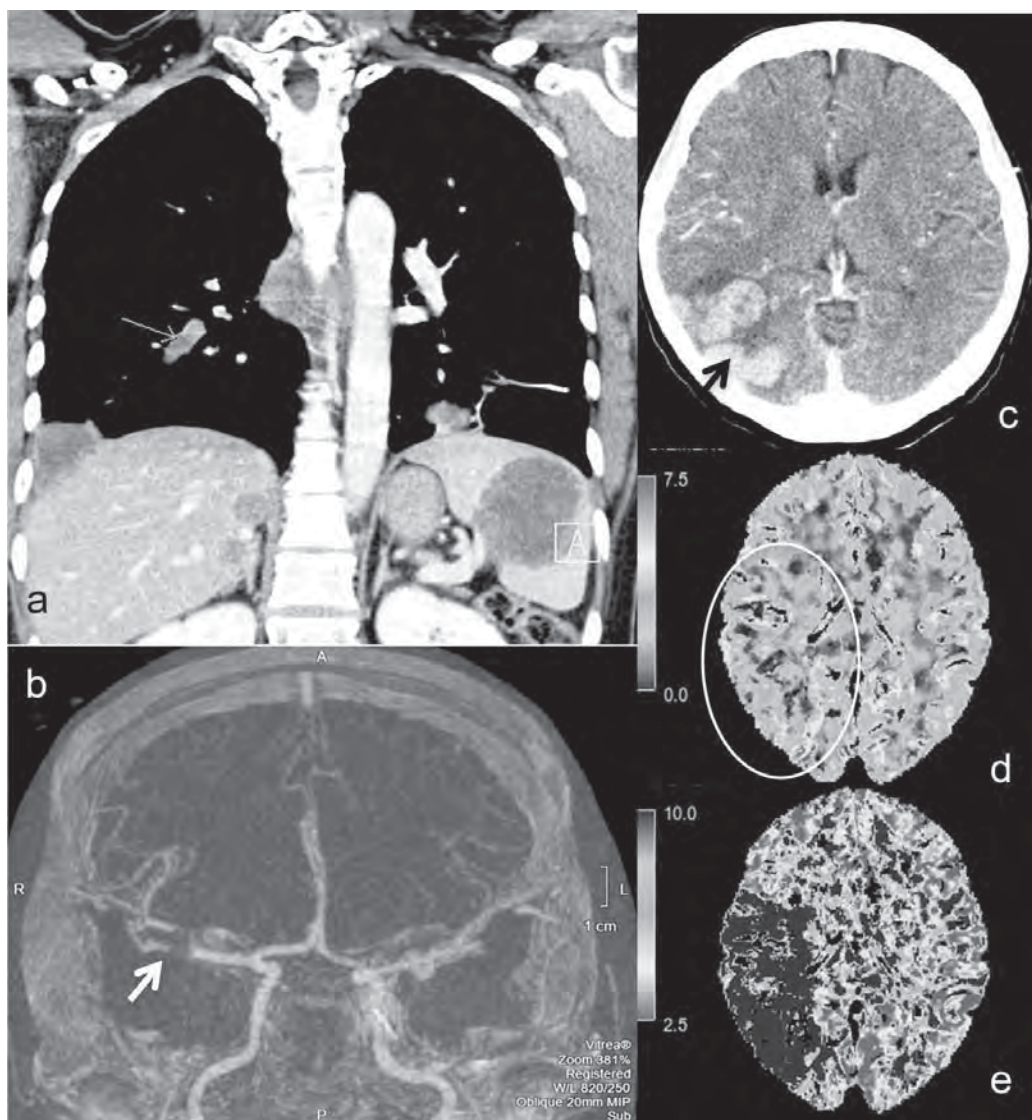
(a) Follow-up whole body CT with contrast, 3 weeks prior to stroke onset, reveals multiple metastases over bilateral lungs, spleen, mediastinal lymph node, together with thromboembolism in the right lower lung. (arrow) (b) CT angiography shows a clot (arrow) in the distal M1 segment of the right MCA with partial occlusion. (c) Brain CT with contrast shows a 5.7 cm lobulated enhancing mass at the right temporo-parieto-occipital lobe (arrow), indicating brain metastases. (d-e) CT perfusion shows prolonged mean transit time at the right fronto-parieto-temporal lobe with preserved cerebral blood volume. (as indicated of the white-circled region)
